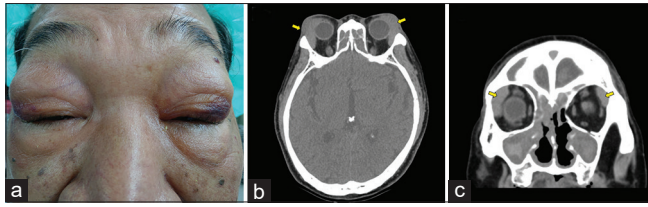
(a) Bilateral large orbital masses over lacrimal glands (b and c) computed tomography revealed the tumors over bilateral lacrimal glands without adjacent structure involvement (arrows)
